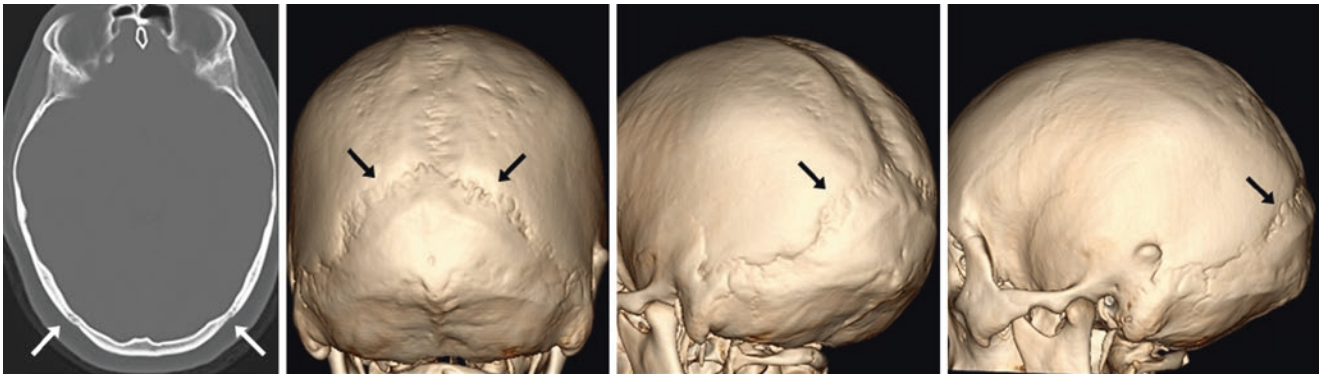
A 16-year-old female patient was concerned about a dent she felt in her skull. While normal lambdoidal sutural fusion (*arrows*) was noted on axial CT (*left*), bathrocephaly was noted on multiple 3D reconstructions of the skull (*right three images*). Note the degree of indentation of the lambdoidal suture, which can be one feature of bathrocephaly
